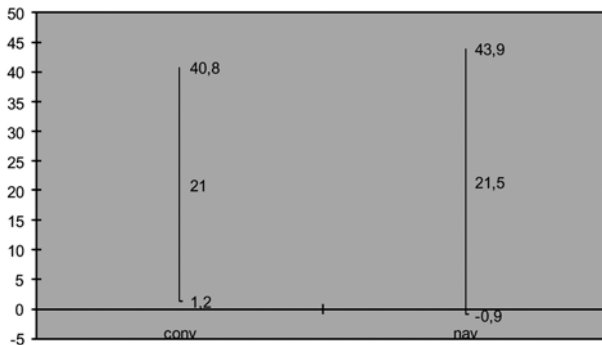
Postoperative rotational alignment of tibial component (rotational position in degrees : angle between transverse axis of tibial implant and digital CT based approximation of transverse axis of the proximal tibia at the level of the tibial tuberosity). Mean values and 95% confidence intervals. Negative values represent internal rotation. The rotational position of the tibial implant was not navigated.
